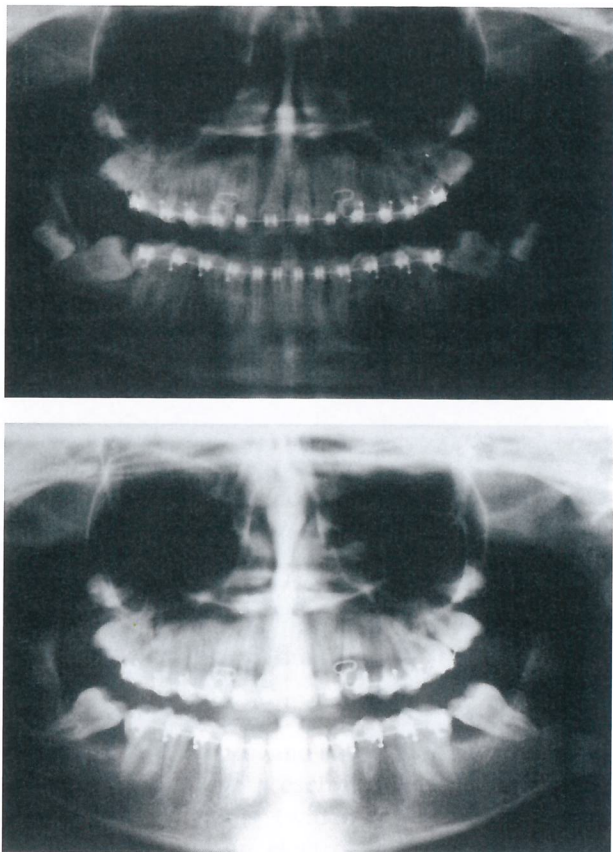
Preoperative (top) and postoperative (bottom) panoramic radiographs showing extraction of the lower third molars and uprighting of the second molars.
